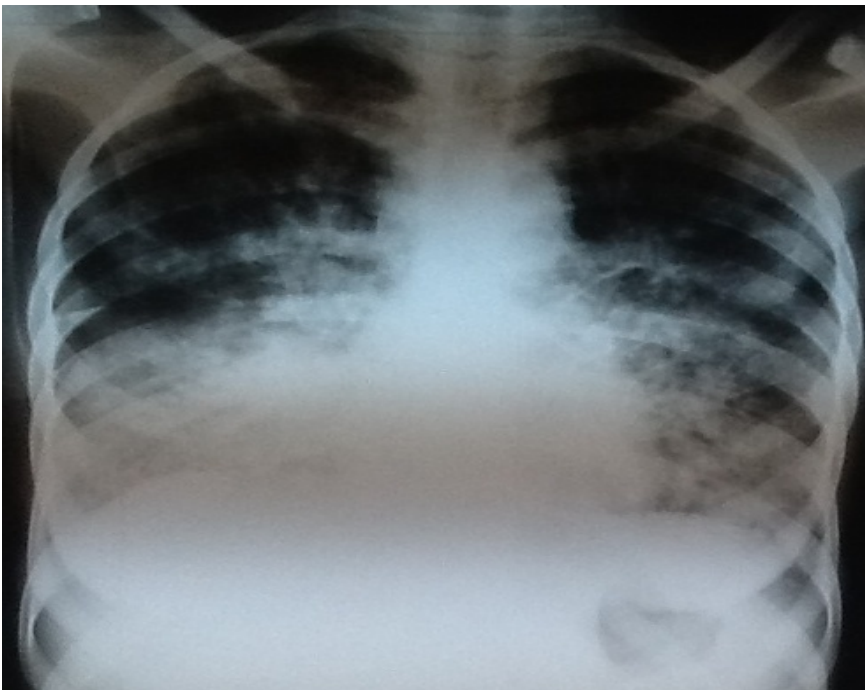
PA chest radiograph of 48 year old patient showing bilateral mid and lower zones non homogenous opacities. VL = 242,152 copies/ml
